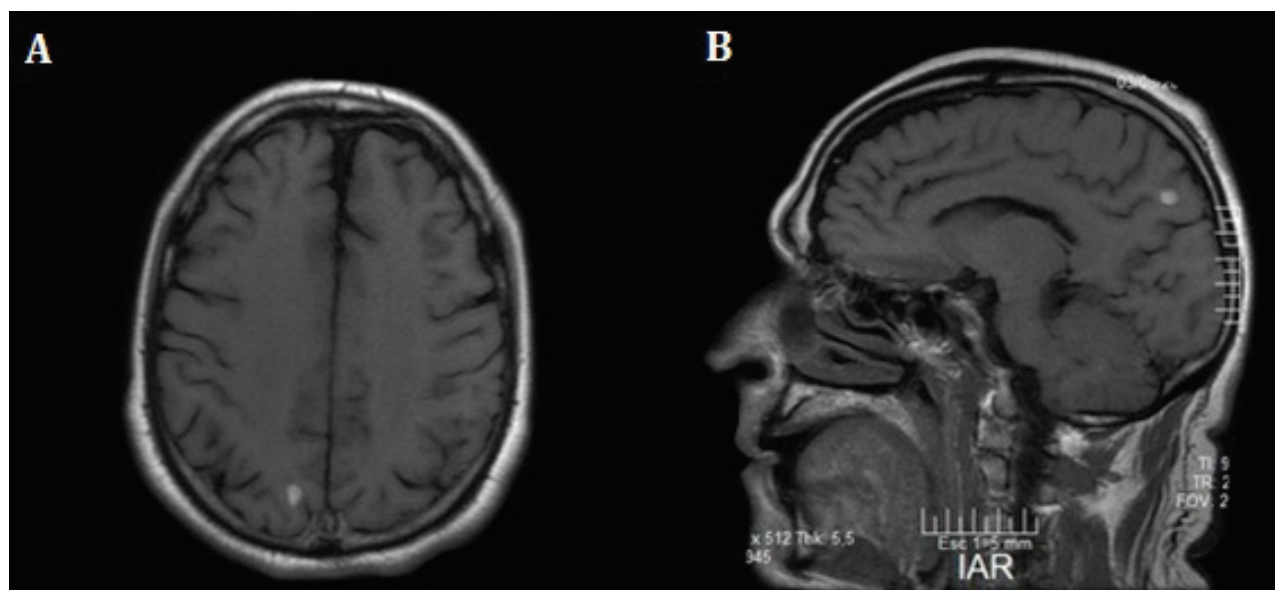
Axial (A) and sagittal (B) T1-weighted magnetic resonance imaging (MRI) of the patient demonstrating a hyperintense lesion in right parieto-occipital region in favor of acute blood or brain contusion.
